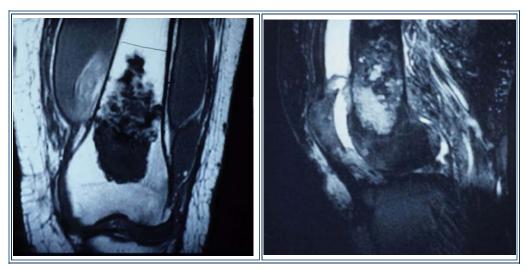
MRI images of distal femoral chondrosarcoma.
